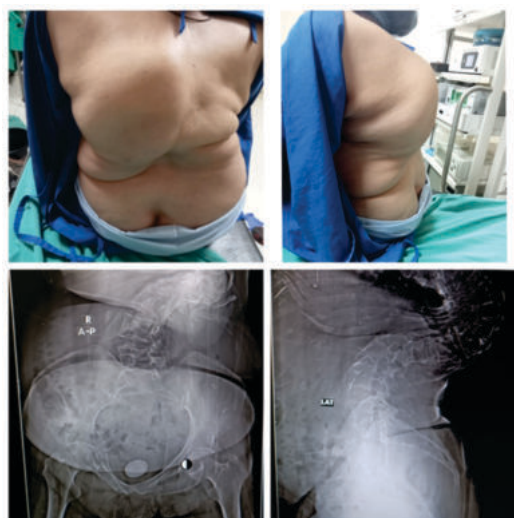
Physical Appearance Of Kyphoscoliosis With X-ray Images.
